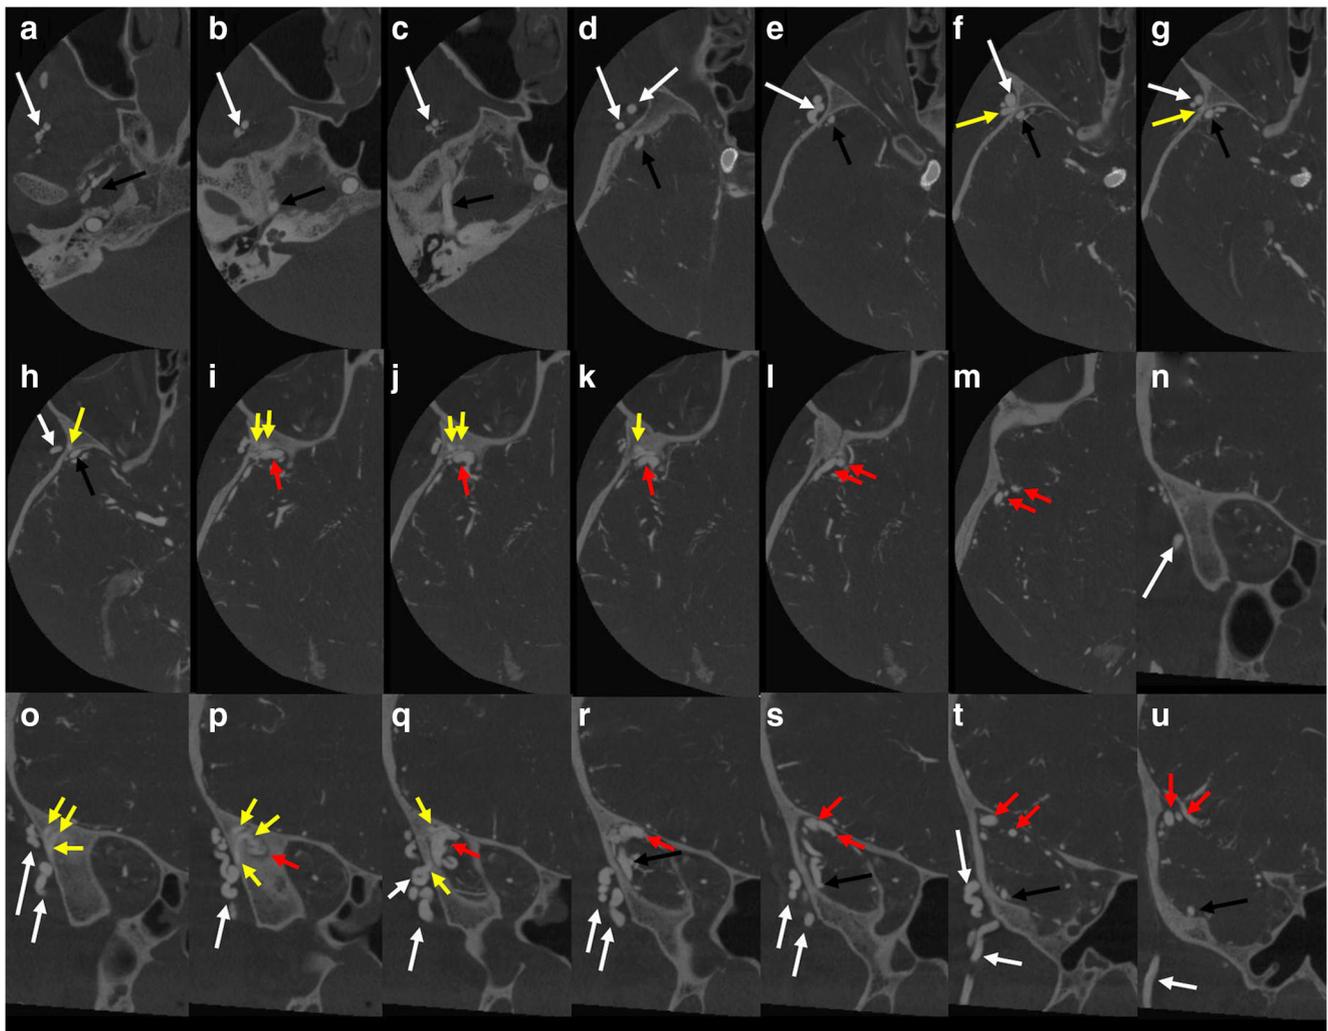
The axial (a–m; caudal to cranial) and the coronal (n–u; anterior to posterior) images of the cone beam CT (XperCT) reconstructed from the 3D rotational angiography via the right internal carotid artery. The current
